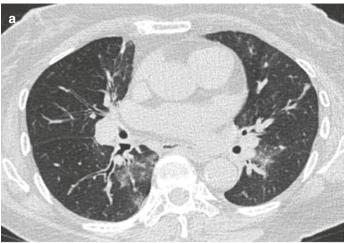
Aspiration changes in a patient with scleroderma. (a, b) Axial CT images show dilated esophagus with air-fluid level (asterisk) with bilateral peribronchial ground-glass opacities. The opacities
